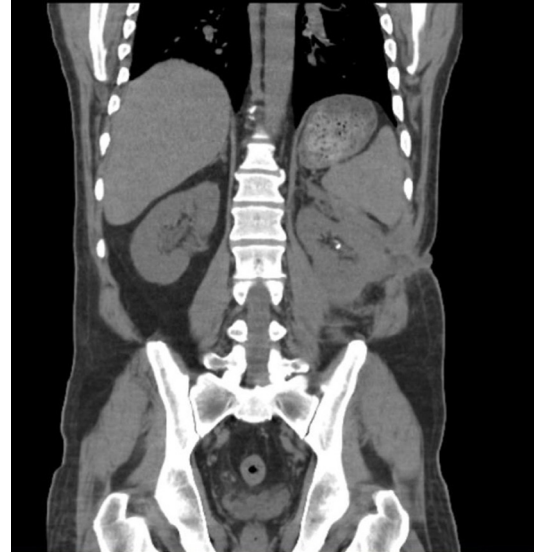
Follow-up abdominopelvic CT scan without contrast.
